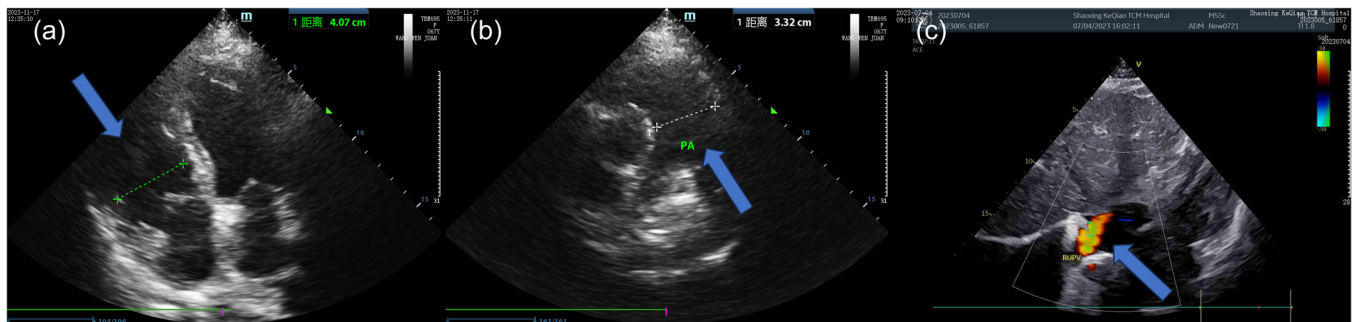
(a) Parasternal long axis view shows an enlarged right ventricle (arrow). (b) Suprasternal view depicts dilation of the main pulmonary artery (arrow). (c) Apical four chamber view on right ventricular contrast echocardiography demonstrates retrograde flow from the right pulmonary vein into the right atrium via the superior vena cava (arrow), correlating with scimitar syndrome anatomy.
